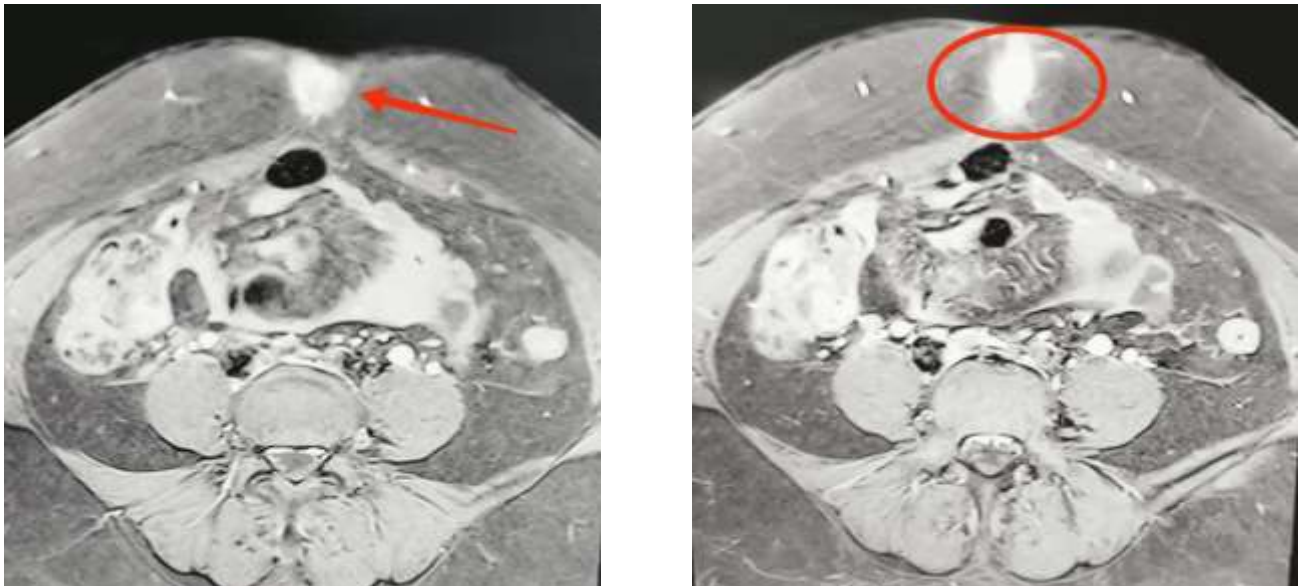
Pelvic MRI images of the patient showing a subcutaneous hypersignal T2 (red arrow and red circle), referring to endometriosis in the umbilical area.
